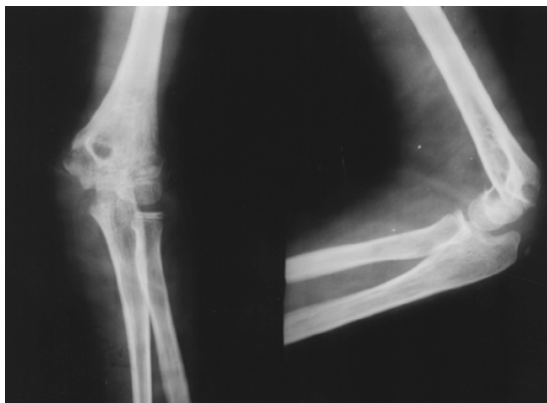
Preop. AP. and Lat. X-ray.
